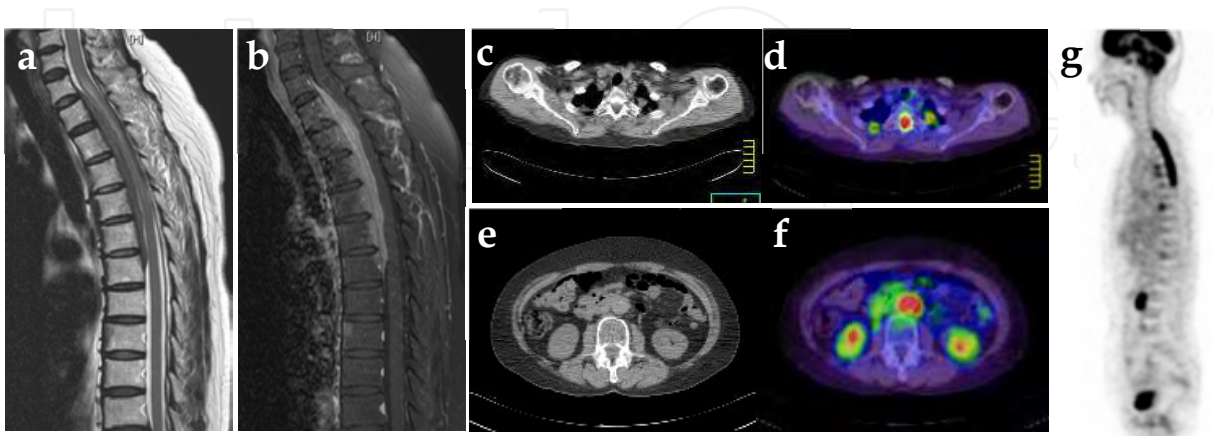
MRI showing a diffuse space-occupying lesion at the anterior spinal cord: T2-weighted MRI (a); Gd-enhanced (b). Axial CT (c,e); axial PET/CT fusion (d,f) and sagittal PET image (g) demonstrating FDG uptake in the abdominal aorta and bilateral upper lungs.
